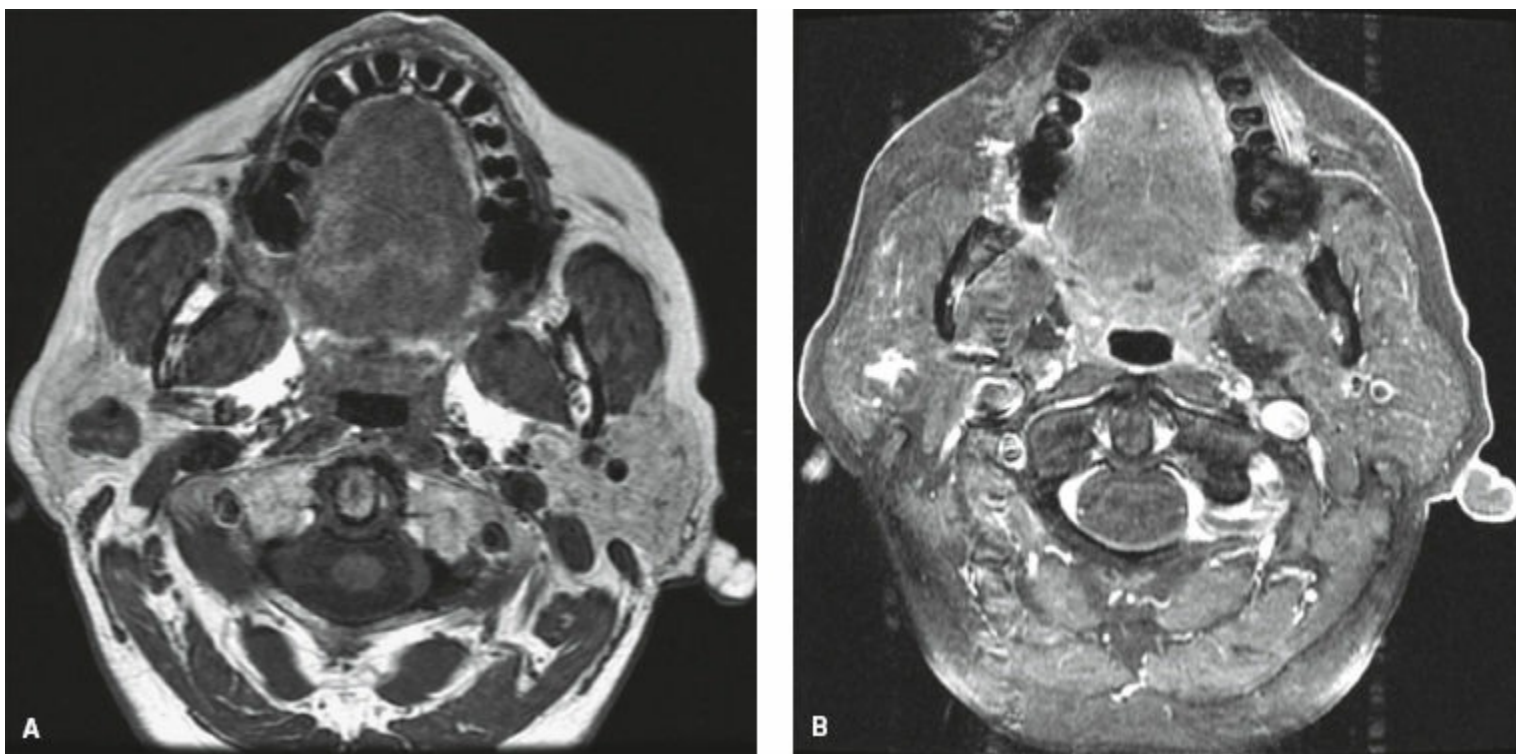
Precontrast (A) and postcontrast (B) T1 MRI demonstrate a lobulated, heterogeneous mass within the right parotid gland just posterior to the retromandibular vein, consistent with a pleomorphic adenoma.
